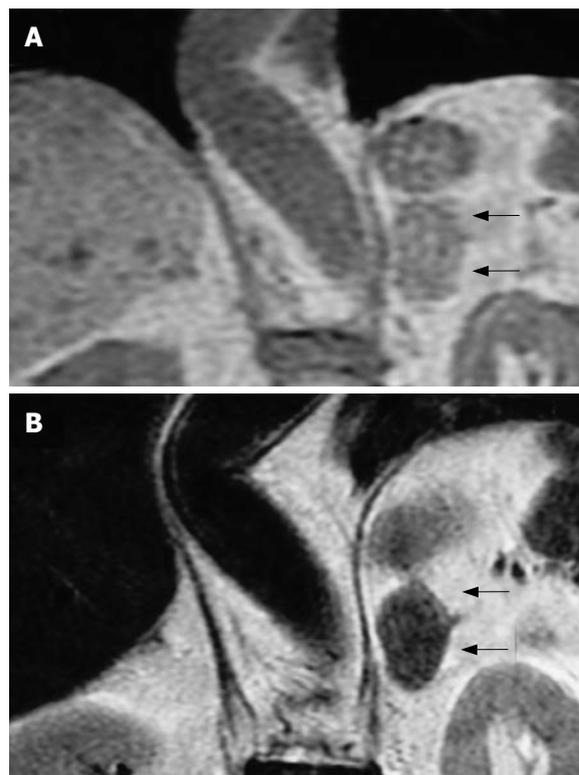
Abdominal MRI. MRI showed an adrenal mass (black arrow) with slightly low intensity on T1-weighted images (A) and low intensity on T2-weighted images (B).
